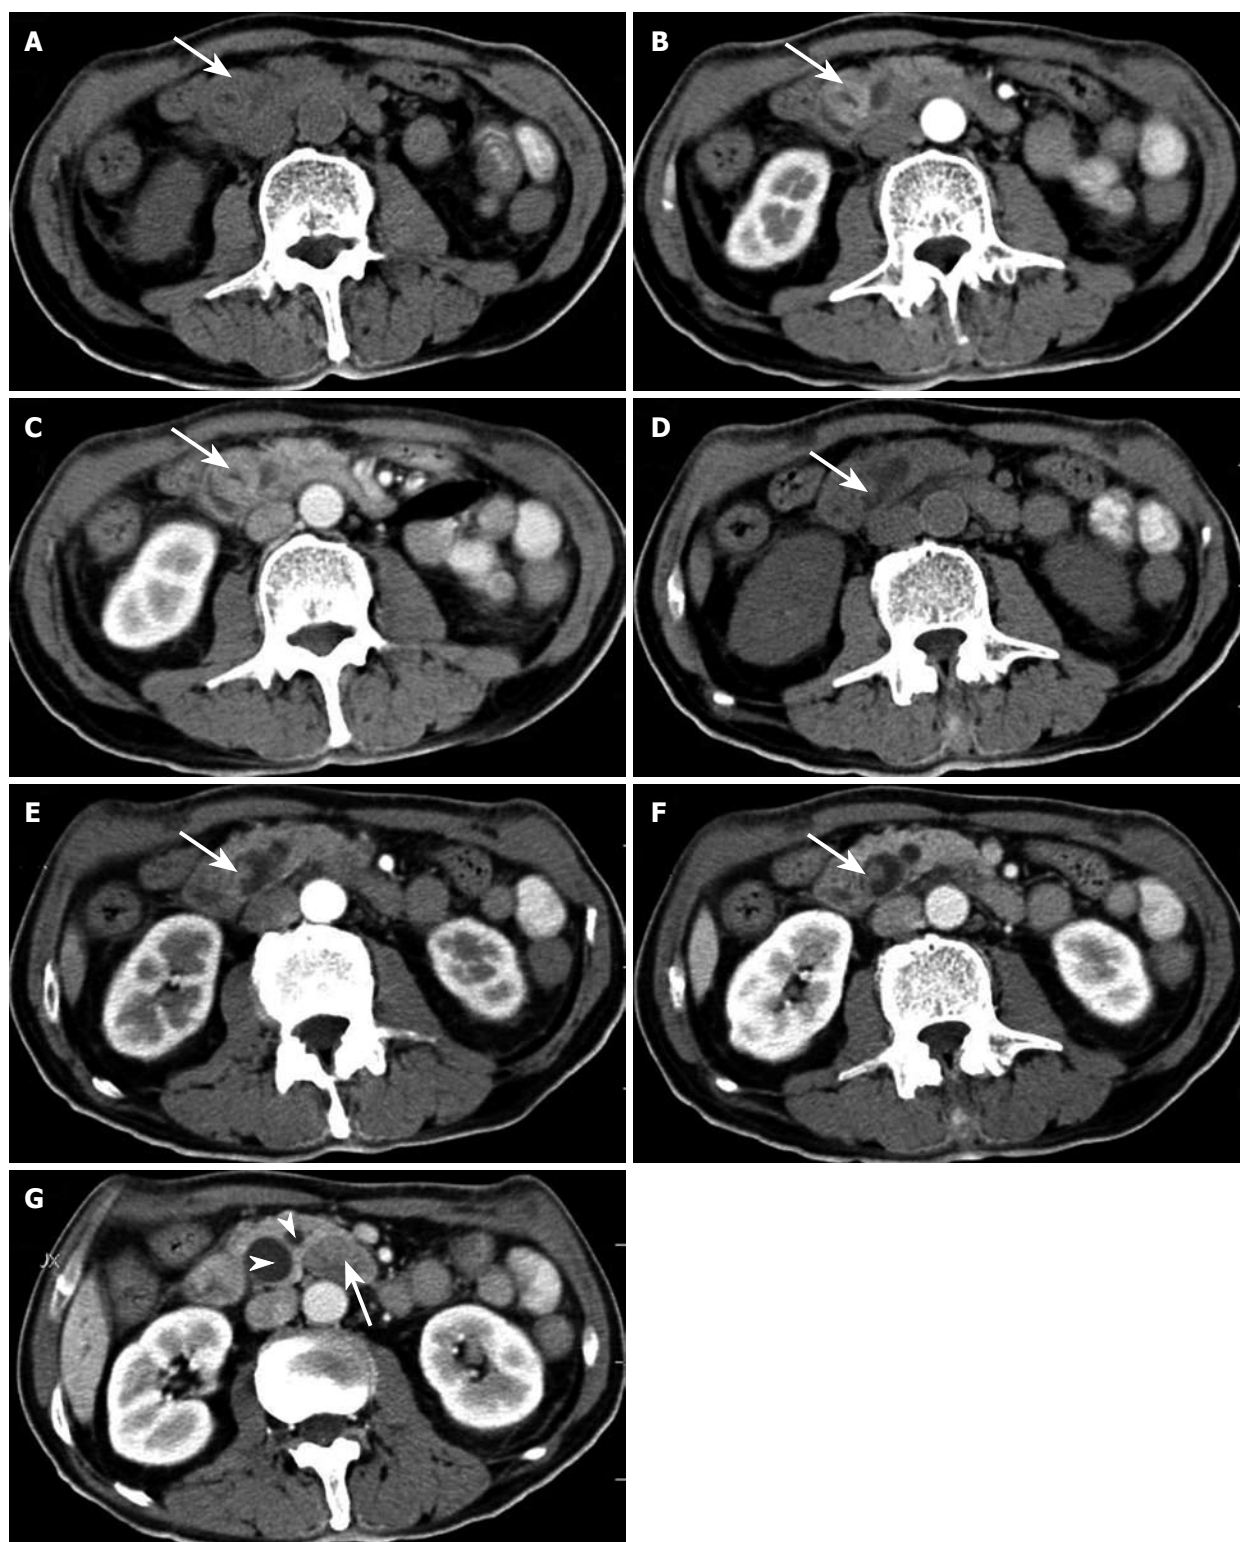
Abdominal CT reveals two well-defined masses in the ampulla of Vater. On precontrast CT scanning, the two masses (arrow) show isoattenuation to the surrounding pancreatic parenchyma (A and D). On arterial and portal phase images after contrast enhancement, the larger oval mass (arrow) shows slightly higher attenuation than the surrounding pancreas (B and C). The smaller polypoid mass (arrow) with a long pedicle and stalk shows slightly lower attenuation than the surrounding pancreas (E and F). Contrast-enhanced CT scan (G) shows peripancreatic lymphadenopathy (arrow) and dilatation of the common bile duct and the pancreatic duct (arrowheads).
